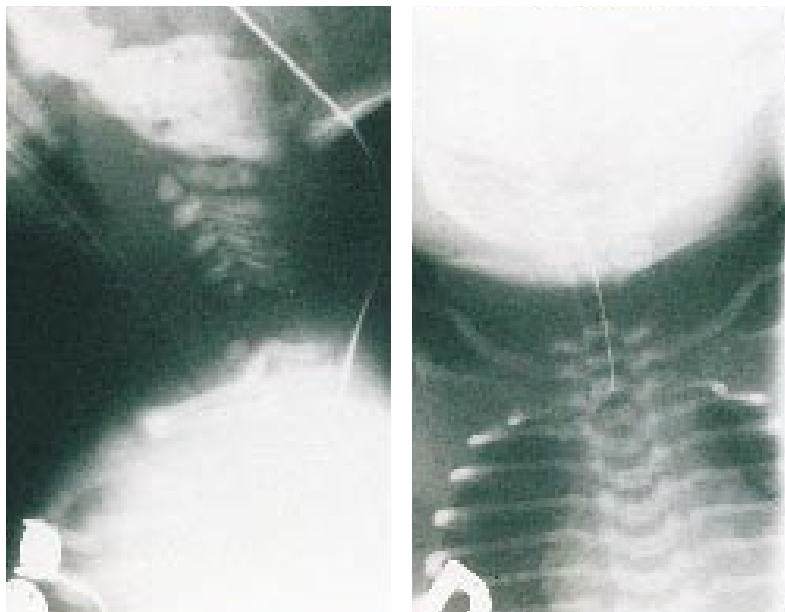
Radiograph of the neck showing the cervical cord and spinal injury following breech delivery. Note the fracture dislocation and separation involving C5 and C6.
